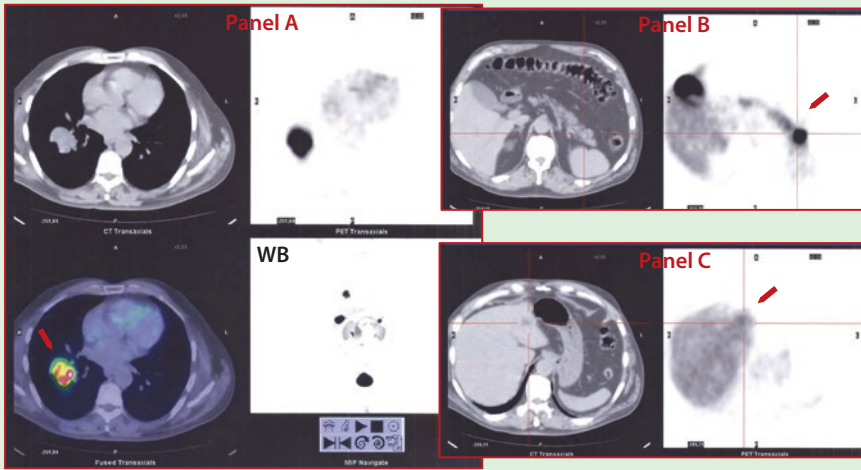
^{18}F -DOPA PET/CT in the proband's father – the right bronchial tumour (Panel a), the NF-P-NETs (Panel b) and to a lesser extent a small hepatic nodule (Panel c) showed a pathological uptake. The whole-body PET scan is also shown (Panel a, WB)
